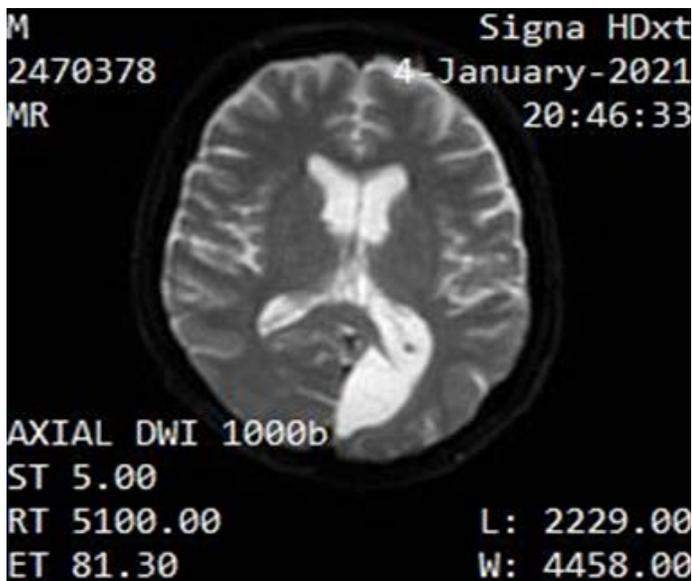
The appearance of a Porencephalic cyst in MR imaging of the patient
